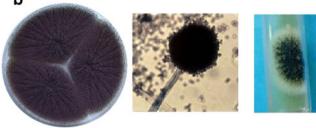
Pulmonary aspergillosis and *Isospora belli* infection in CD40L-deficiency. a Computed tomography (CT) scan of the chest showing Aspergillus lung infection in P14. b Images showing growth of *Aspergillus niger* from sputum cultures of patient P25. c Cachectic state of patient P16 after recurrent diarrhea caused by *Isospora belli*
